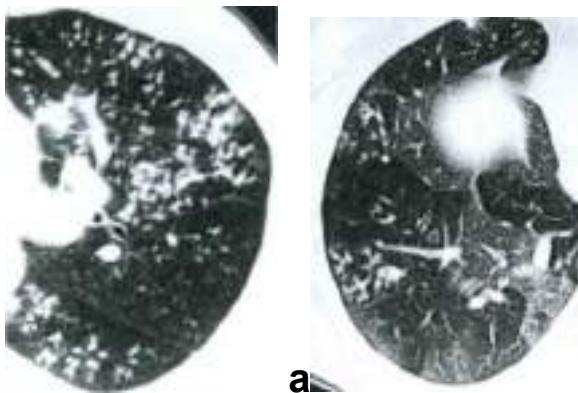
CT variants of infectious bronchiolitis.
